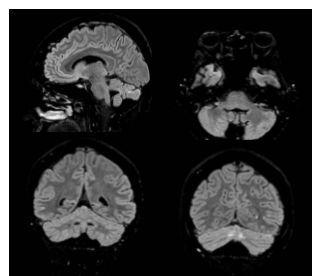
Follow-up Brain MRI
